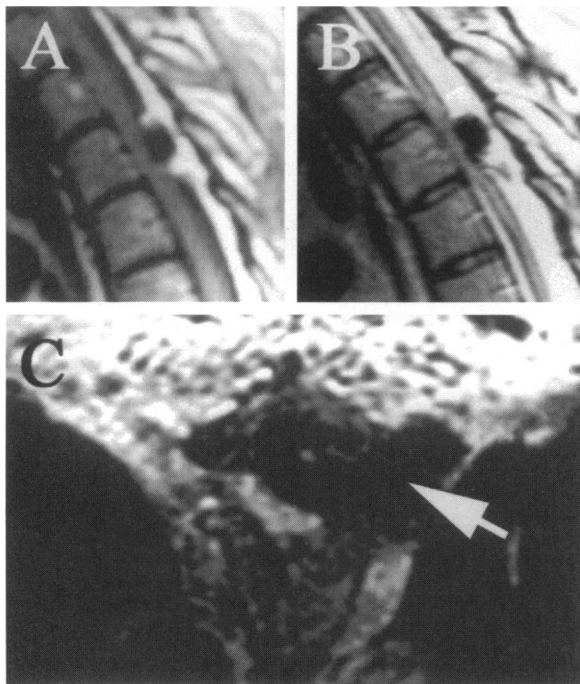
MRI of Surgicel® compression (case 2). (A) T1- and (B) T2-weighted MR images show a hypo-intense intraspinal extradural mass. (C) The axial T1-weighted MR image shown indicates the mass of Surgicel® not only within the canal but also extending along the foramen (arrow).
